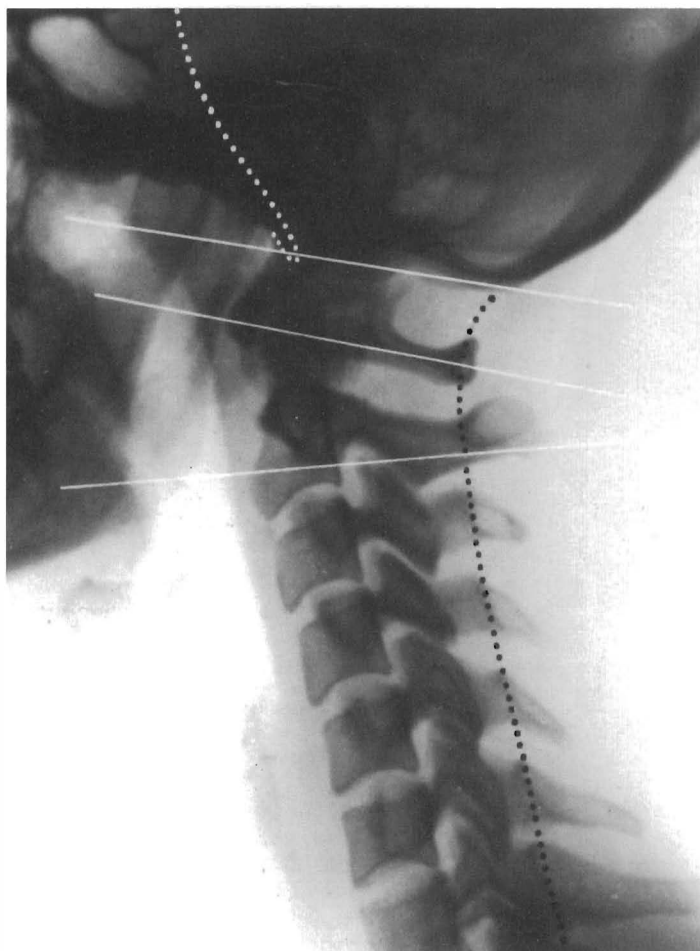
Lateral X-ray of the cervical spine with the plane of the foramen magnum, the atlas and the axis indicated; the clivus and the posterior edge of the vertebral canal are also shown
